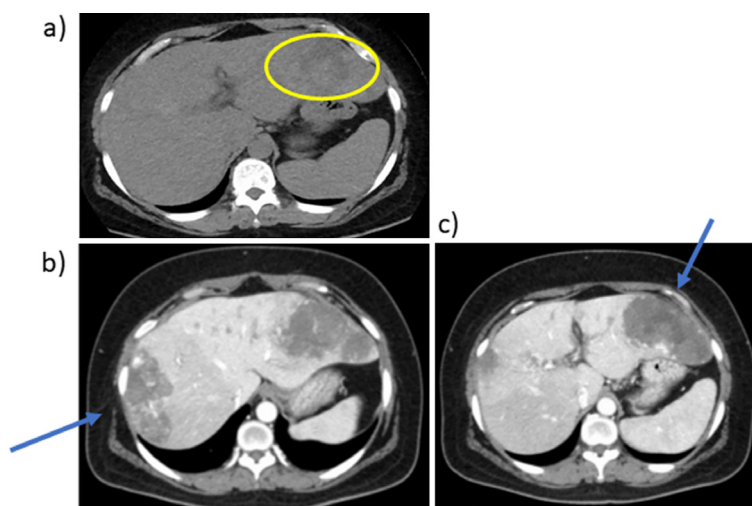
Abdominal CT findings. a) Plain CT. b, c) late phase of enhanced CT. Plain CT of the abdomen showed slightly high intensity inside the mass (a, circle). Hepatic masses of 10 cm in size in liver S8/7 (b) and S3/2 (c) with prolonged enhancement suggesting hepatic hemangiomas (arrows). Imaging examination revealed no other abnormalities. CT: computed tomography
